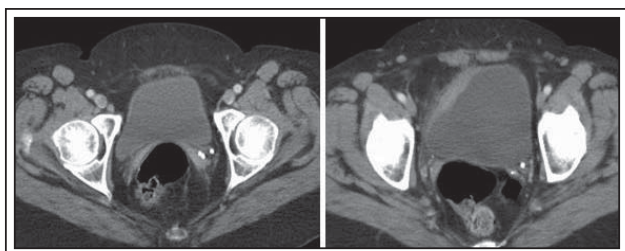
CT scan of bladder, pre-resection on the left, post-resection/post MM-C on the right.
